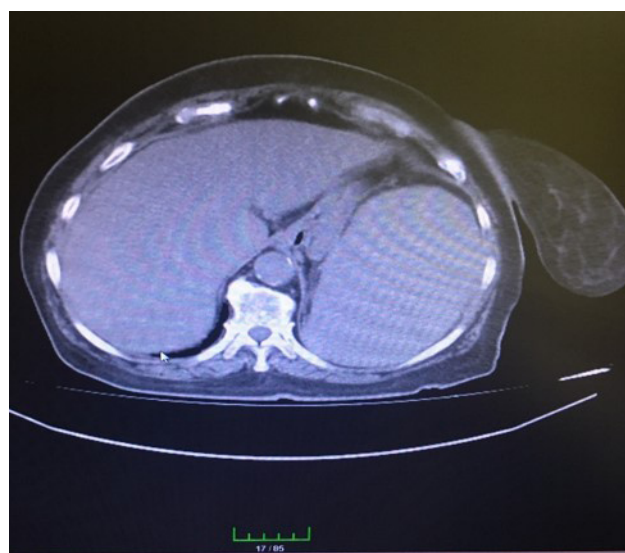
Abdominal CT images of case 2 at the time of diagnosis showing organomegaly, ascites, intraabdominal lymph nodes and right mastectomy.
